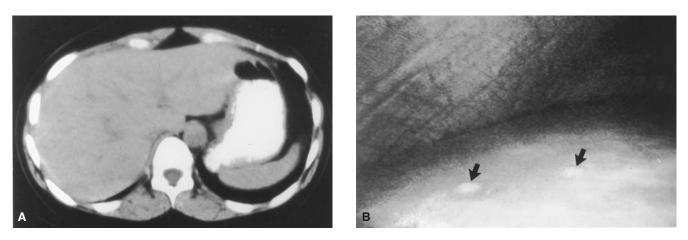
A*, Computed tomographic (CT) scan of the liver of a patient with multiple endocrine neoplasia type IIA, recurrent medullary thyroid carcinoma (MTC), and elevated calcitonin levels. There is no evidence of liver metastases on the scan. *B*, Laparoscopic view of the liver of the same patient showing multiple small raised whitish lesions on and just beneath the surface of the liver, confirmed to be metastatic MTC by biopsy. These small multiple metastases (*arrows*) are often not seen on routine CT scanning or other imaging modalities, including nuclear scanning. Reproduced with permission from Tung WS et al.¹⁹
